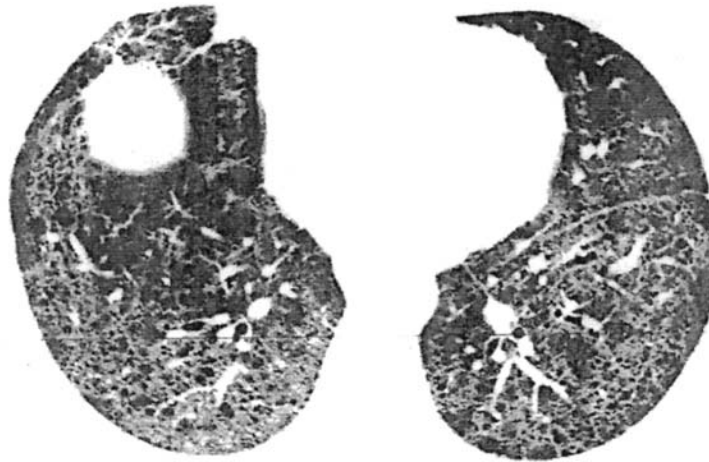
UIP. HRCT (lower lobes) demonstrates ground glass opacities, honeycomb change, and traction bronchiectasis.
